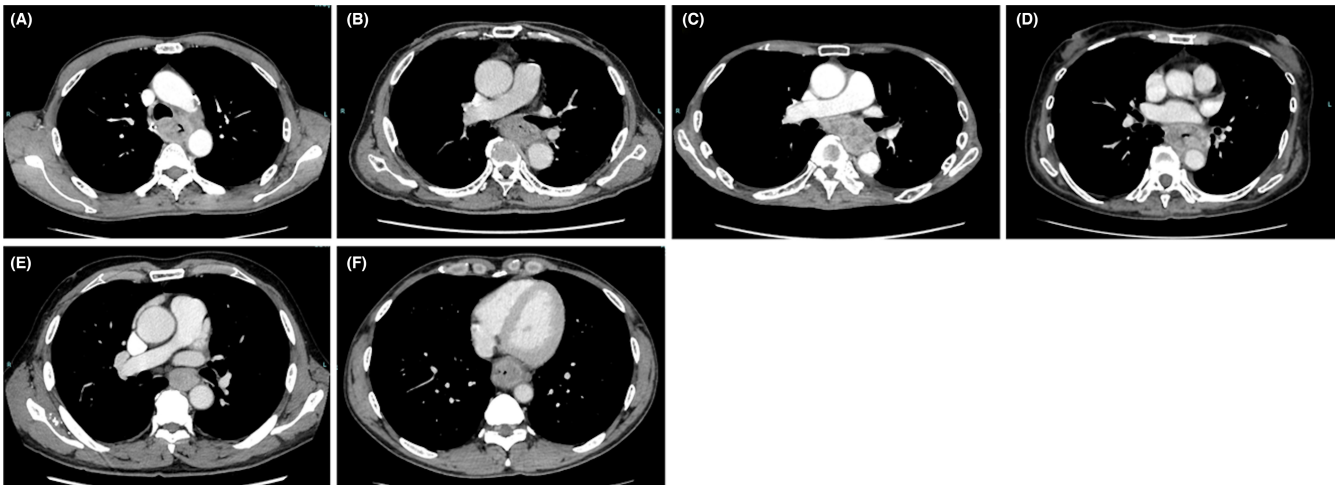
Representative CT findings for patients with (A–D): borderline resectable (cT3br) or (E, F): resectable (cT3r) esophageal cancers.
